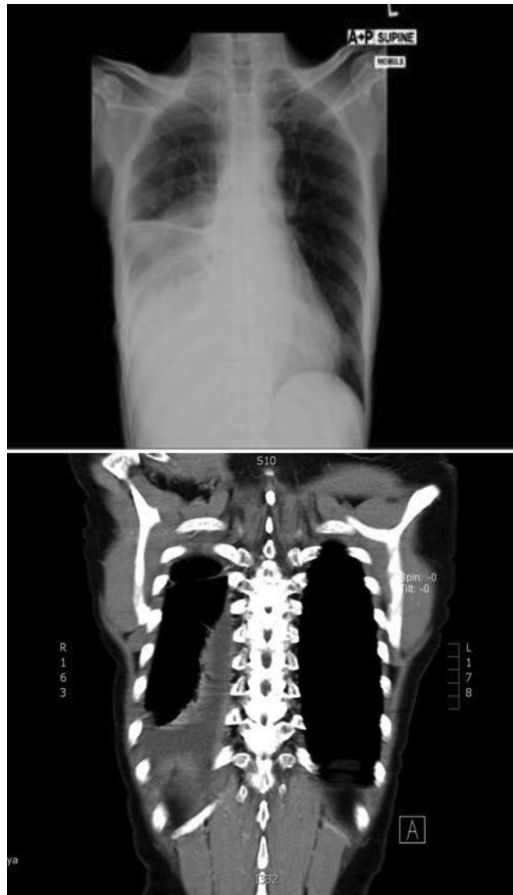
and Fig.2: Chest radiography (left) and CT scan of the patient shows a right pleural effusion (right)
